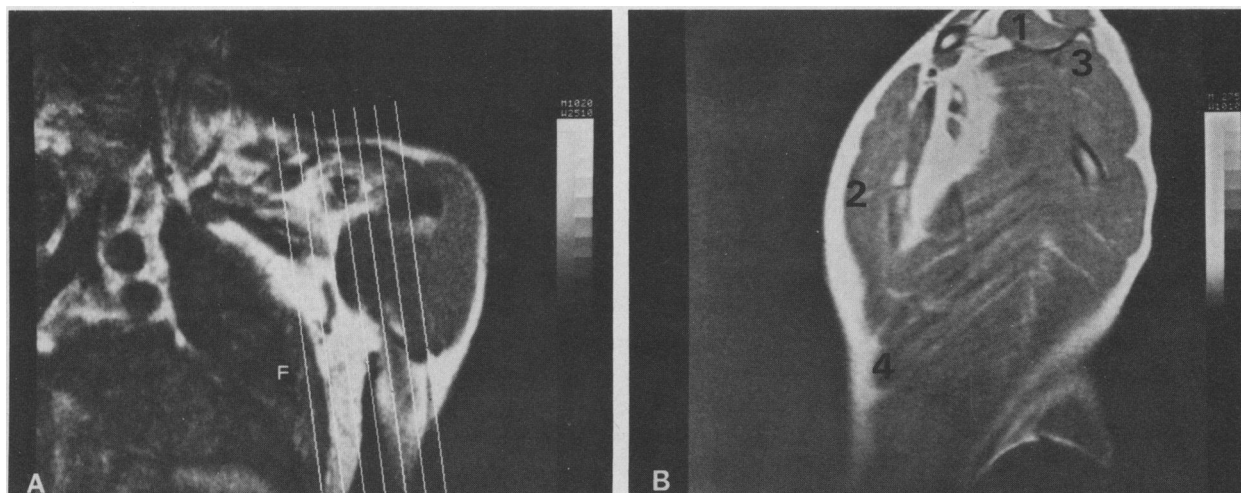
Magnetic resonance imaging of chest. Coronal view (A) with cursor lines in place to demonstrate the level of the image (arrow). Oblique shoulder view of the chest (B) demonstrating the soft tissue and muscles (Supraspinatus, Pectoralis major, infraspinatus, and serratus anterior muscles)
